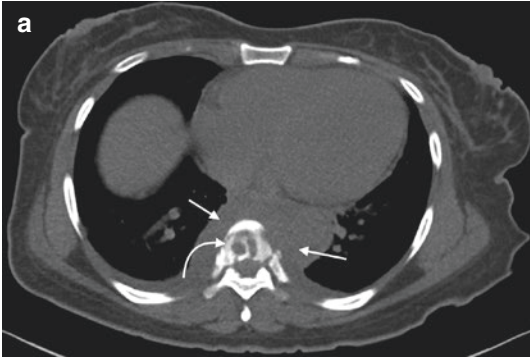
A 41-year-old female with history of intravenous drug abuse and severe thoracic and abdominal pain. Axial CT image (a) from an abdomen CT study shows concentric areas of osteolysis within a thoracic vertebral body (*curved arrows*) surrounded by extensive paraspinal soft tissue (*arrows*). A reformatted coronal image (b) shows that the lytic change involves adjacent vertebral endplates (*arrows*). A T1-weighted sagittal image (c) shows loss of the disk-endplate margins (*arrow*) and a ventral epidural soft tissue component (*curved arrows*). The diffuse hypointense marrow signal reflects the patient's chronic anemia. The T2 sagittal image (d) shows destruction of the disk space (*large arrow*) and abnormal vertebral marrow signal involving three vertebral bodies and the posterior elements (*small arrows*). Spinal cord
